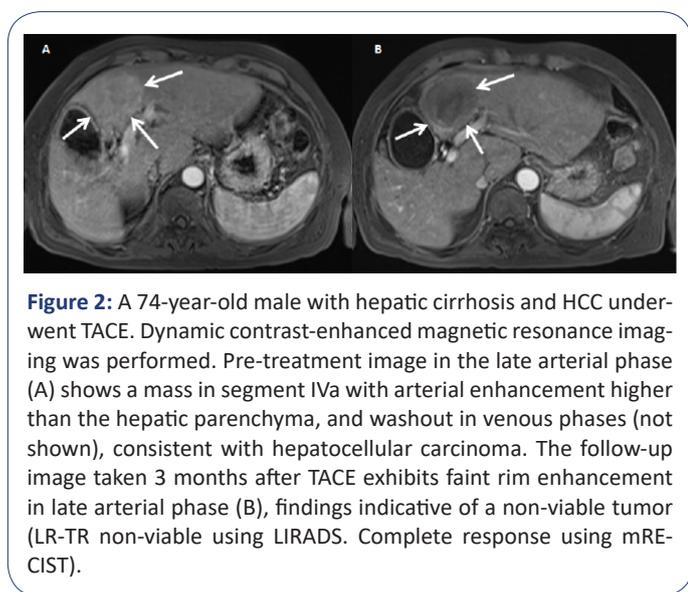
A 74-year-old male with hepatic cirrhosis and HCC underwent TACE. Dynamic contrast-enhanced magnetic resonance imaging was performed. Pre-treatment image in the late arterial phase (A) shows a mass in segment IVa with arterial enhancement higher than the hepatic parenchyma, and washout in venous phases (not shown), consistent with hepatocellular carcinoma. The follow-up image taken 3 months after TACE exhibits faint rim enhancement in late arterial phase (B), findings indicative of a non-viable tumor (LR-TR non-viable using LIRADS). Complete response using mRECIST).
